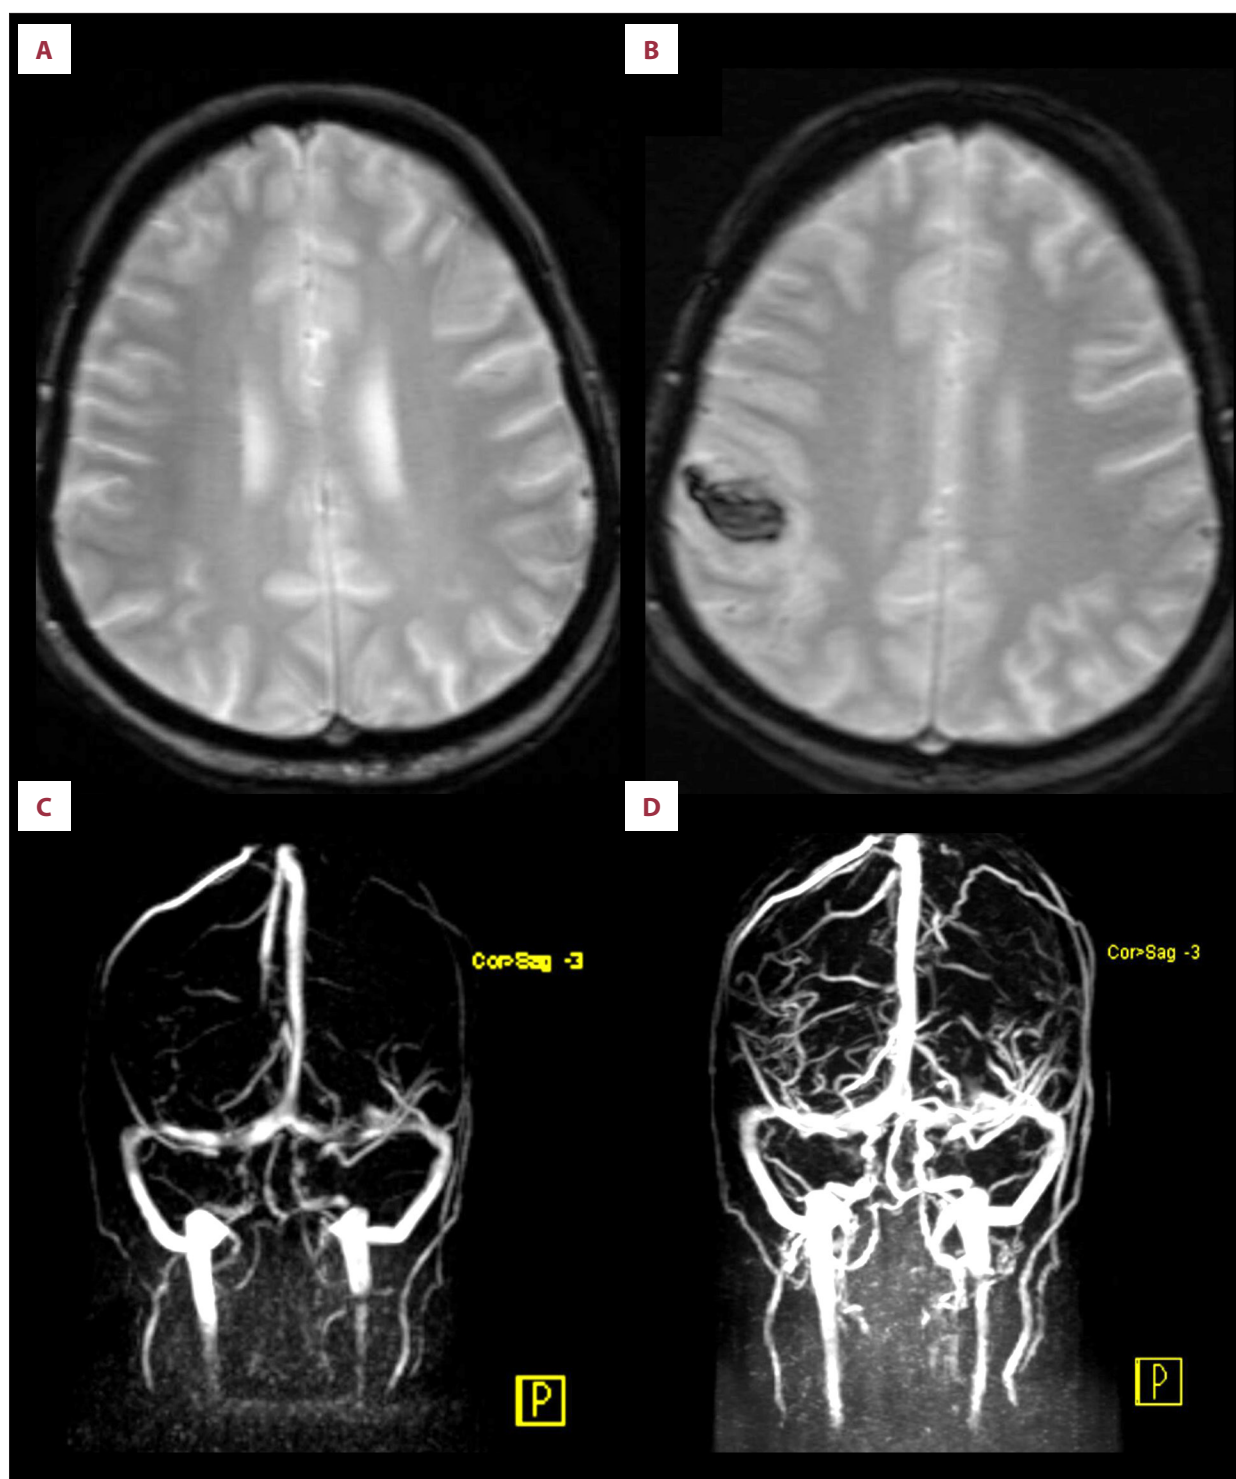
Magnetic resonance imaging (MRI) studies of the brain performed during hospitalization. (A) Contrast-enhanced MRI of the brain on admission demonstrates small, nonspecific foci of altered signal intensity within the bilateral deep and subcortical white matter. No areas of abnormal restricted diffusion are identified. There is no evidence of hyperacute, acute, or early subacute ischemic insult. No extra-axial or intracerebral hemorrhage is seen. (B) Contrast-enhanced MRI of the brain on day 6 of admission reveals a newly developed intra-axial acute hematoma in the right high frontoparietal subcortical region. (C, D) MR venography of the brain performed on day 6 demonstrates occlusion of the right superior anastomotic vein (vein of Trolard), findings consistent with venous hemorrhage.
